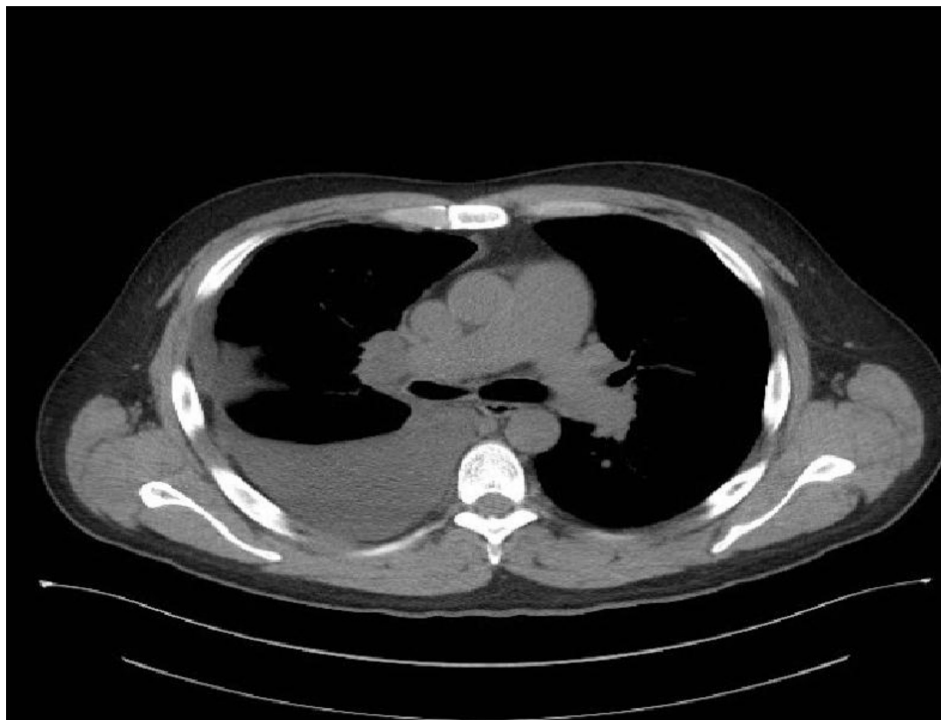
CT scan without contrast showing right pleural effusion and right hilar adenopathy with suggestion of node or mass with size of 3.2×2.2 cm.
